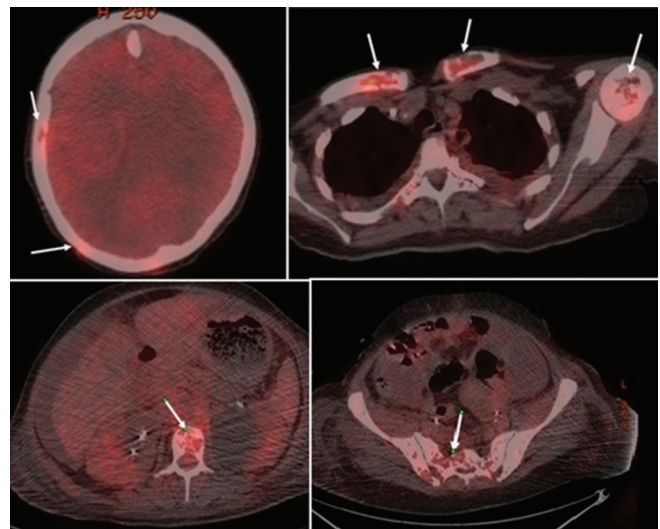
In positron emission tomography-computed tomography scans, there are multiple lytic lesions in myocardium, both clavicles, humeral head, vertebral column, and pelvis
